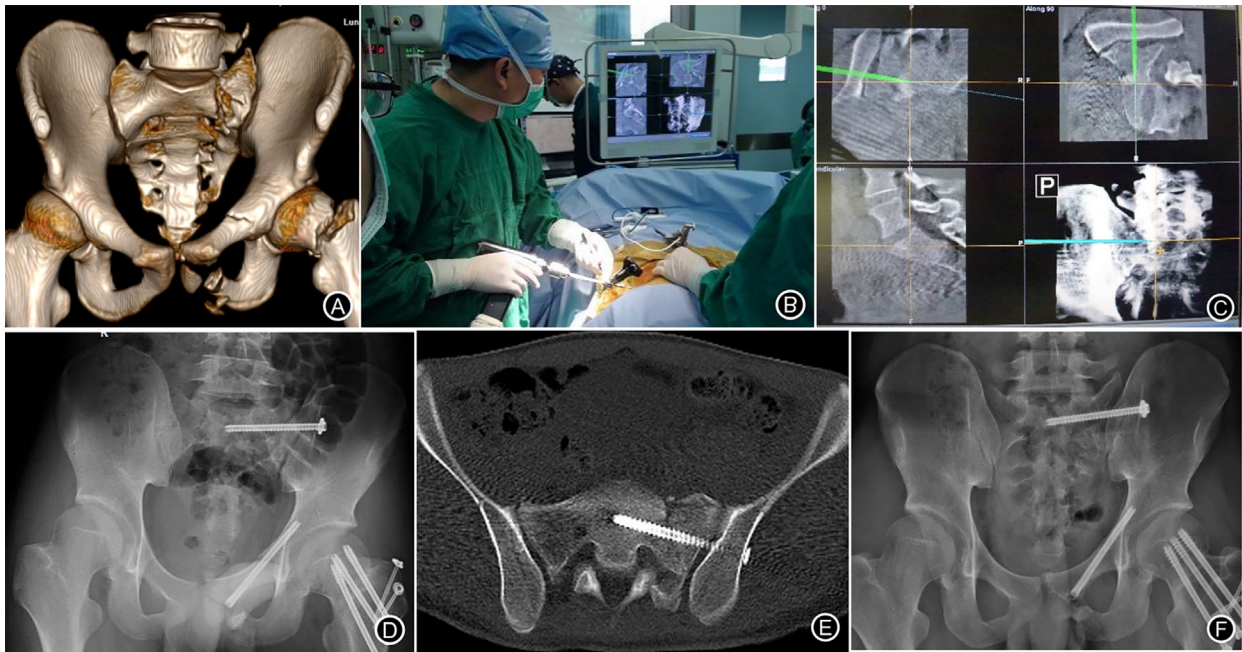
(A) Male, 30 years old, was injured by a traffic accident. The patient accepted operation 5 days after injury. Preoperative three-dimensional computed tomography (CT) showed the left Zone II unstable sacral fractures. (B-C) Intraoperative 3D picture showed the track of IS screw placement. (D) Closed reduction and percutaneous IS screw fixation under 3D navigation was applied to treat Zone II unstable sacral fractures, and the pubic rami fracture was treated with intramedullary fixation. (E) Postoperative axial plane view of CT showed the sacral fracture had anatomic reduction and position of IS screw was excellent. (F) Radiographs of 6 months postoperatively showed the sacral fracture complete union
